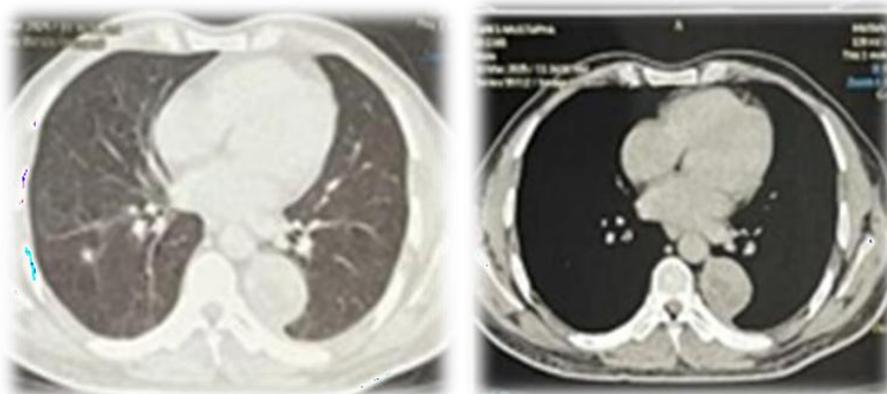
Axial chest computed tomography (CT) images
